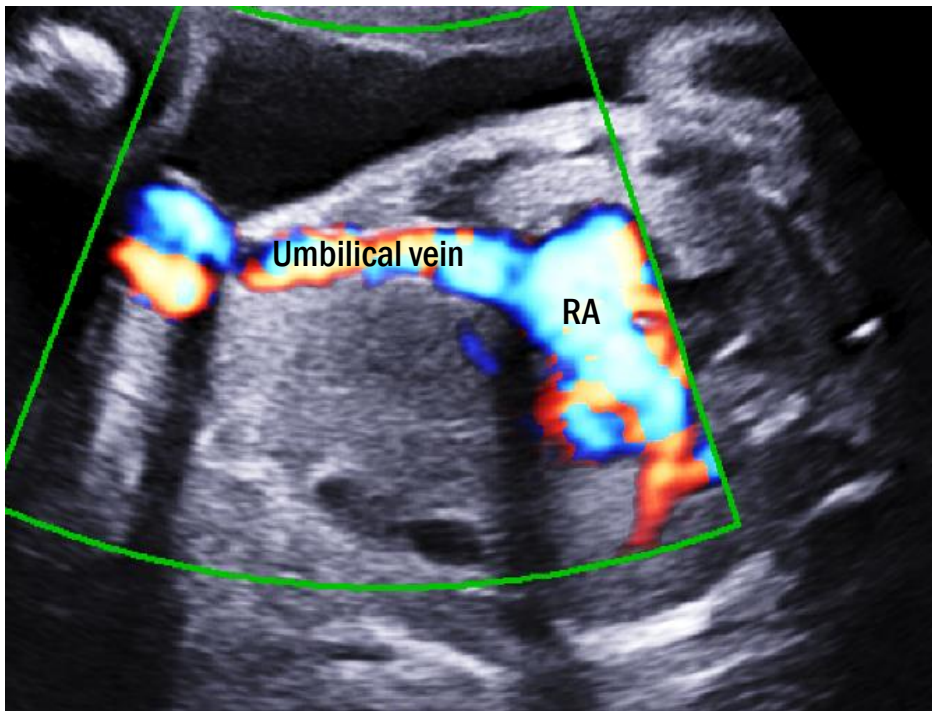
Two-dimensional color Doppler image of type I umbilical-portal-systemic venous shunt in case 7. Umbilical vein directly drains into the right atrium without going through the ductus venosus. RA, right atrium.
